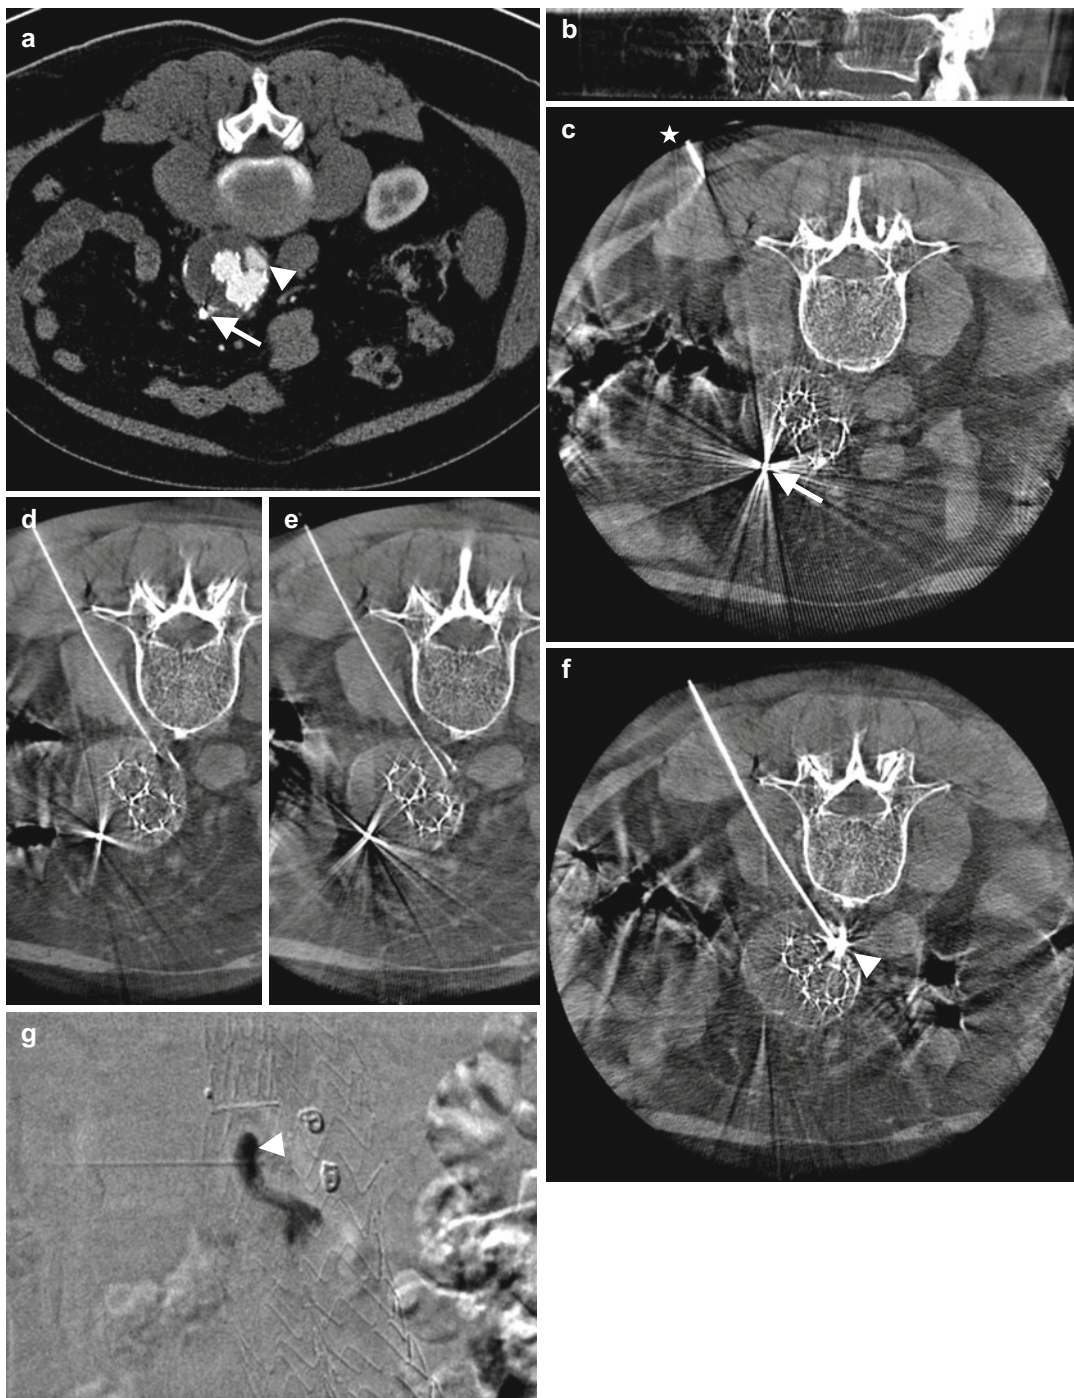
Percutaneous puncture of a type II endoleak after EVAR. (a) 3-mm MPR of the lower abdomen MSCT shows the contrast-enhanced endoleak (*arrowhead*) at the level of the previously coil-embolized inferior mesenteric artery (IMA, *arrow*). (b, c) Sagittal and transversal 3-mm multiplanar reconstructions of the unenhanced C-arm CT using slab acquisition to cover only the needle (*asterisk*) and the immediate surroundings. The puncture site was
